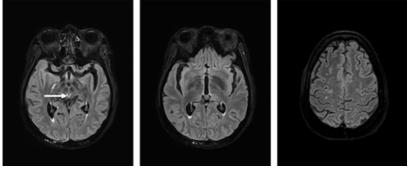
Control MRI at 3 weeks showing persistent Flair hyperintensity of periaqueductal region (arrow) and regression of other signal anomalies.
